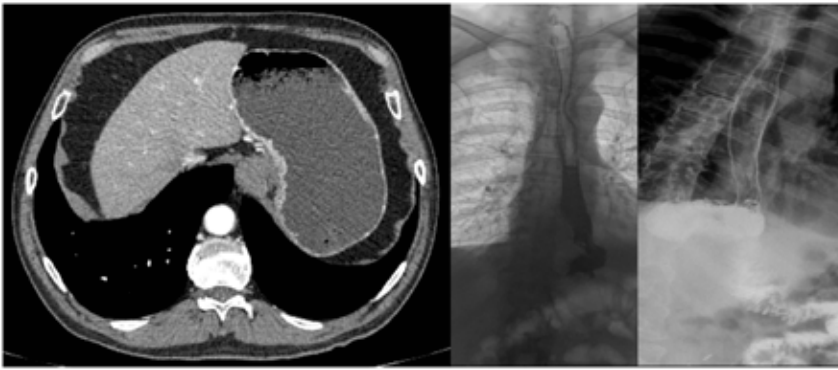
Preoperative CT of the abdomen (far left) and postoperative oesophageal radioscopies (middle and right)
